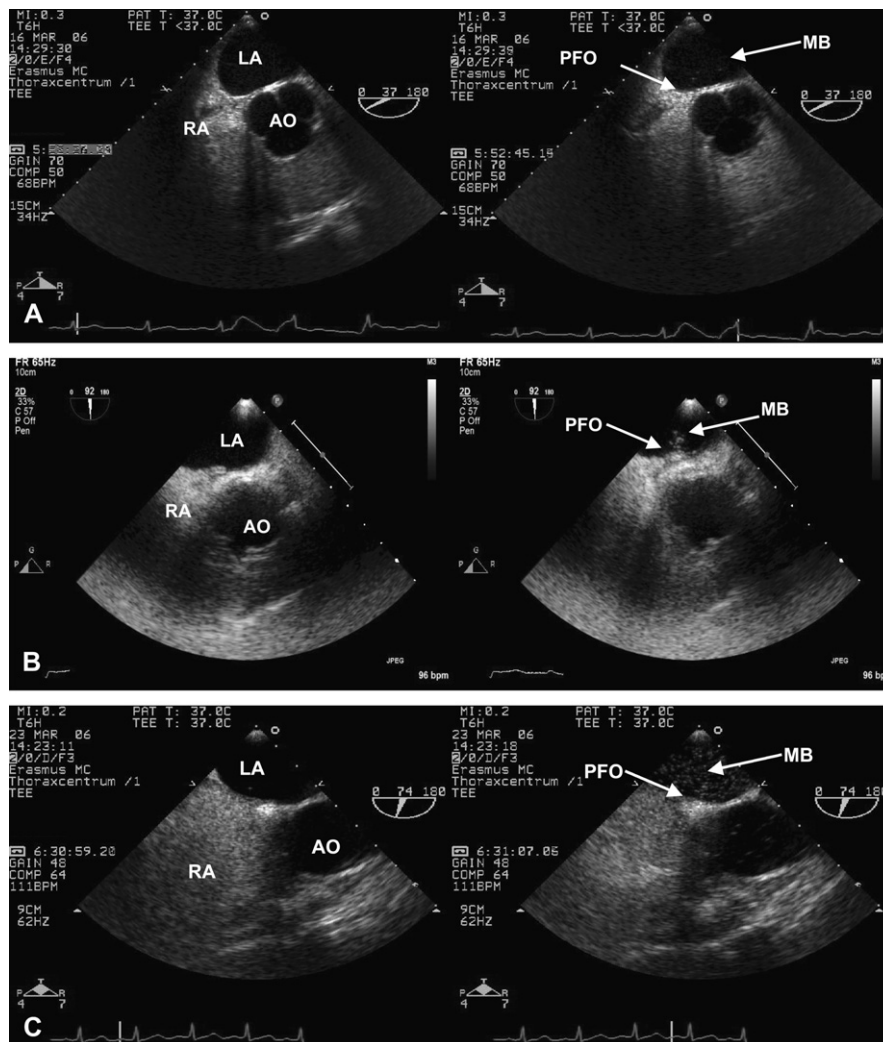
Transoesophageal echocardiography using Haemacel[®] (contrast agent), showing: (A) small-sized (less than 10 microbubbles), (B) small-to-moderate (more than 10 microbubbles), and (C) large right-to-left shunt. Abbreviations: AO = aorta, LA = left atrium, MB = microbubbles, PFO = patent foramen ovale and RA = right atrium.
